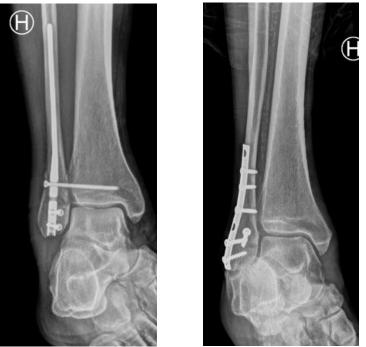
Radiographs of the two fixations for AO/OTA type 44-B ankle fractures. 5a. Mortise view radiograph of AO/OTA type 44-B ankle fracture treated with Acumed fibular nail. 5b. Mortise view radiograph of AO/OTA type 44-B ankle fracture treated with a one-third tubular neutralization plate with lag screw. Department of radiology, Østfold Hospital Trust.
